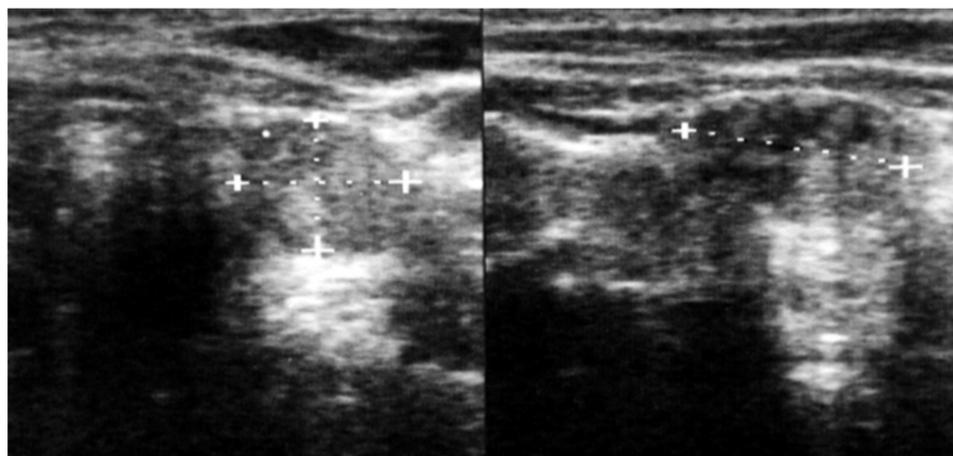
Ultrasound 1 year after the last radioiodine-131 treatment (crosses show the thyroid nodule).
